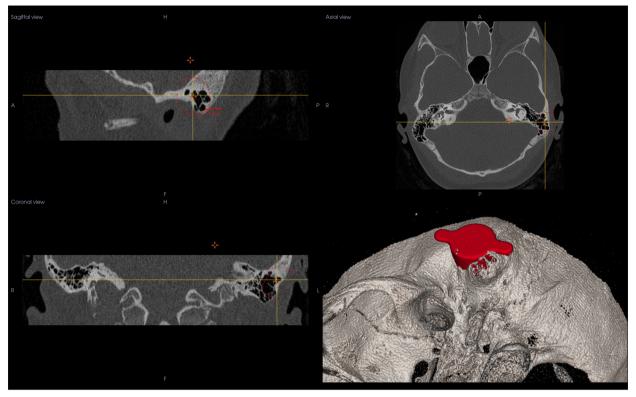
Computed tomography temporal bone assessment.
